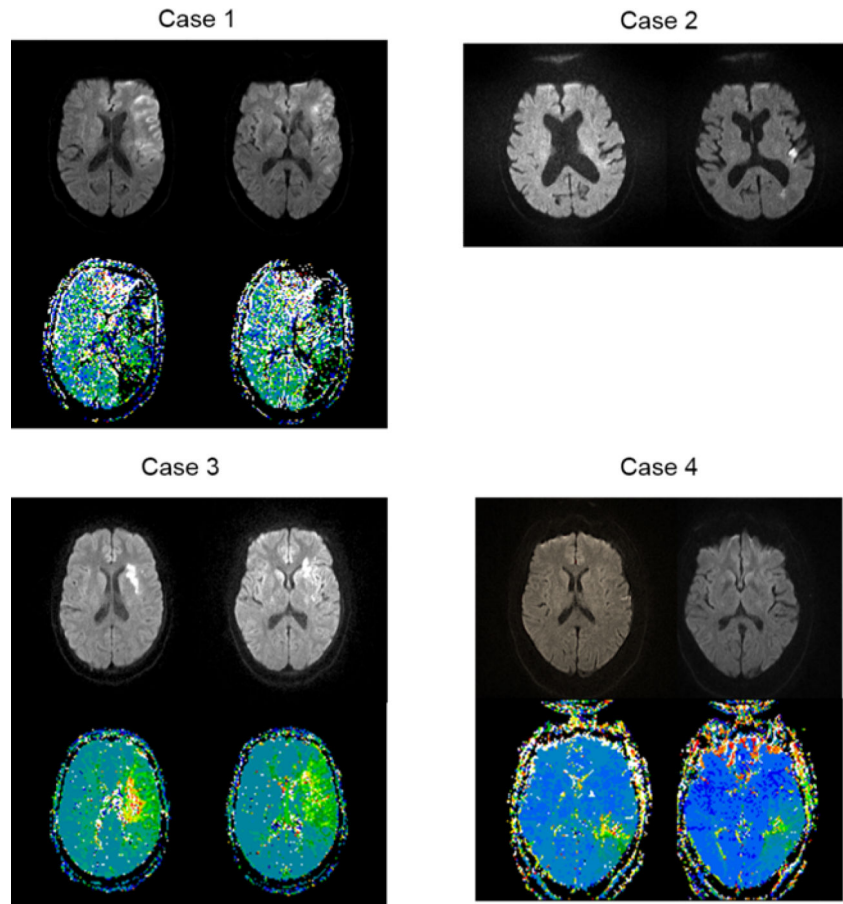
Acute MRI scans of individuals with acute deficits in phoneme discrimination. Scans of patients with impaired phoneme discrimination (by percent error and d' score) at Day 1. Bright areas on DWI (top) are areas dense ischemia/infarct. Yellow/green areas in PWI (lower scans) are areas of significant hypoperfusion (>4 sec delay in TTP).
